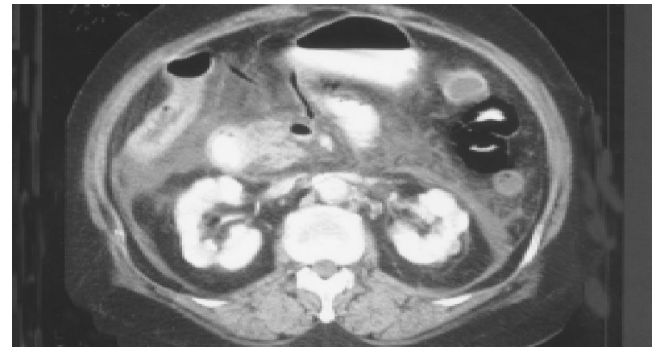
Contrast-enhanced abdominal CT at renal hilar level shows tubular dry gases (arrow) and air-fluid level (arrowhead) within the mesenteric veins. Pneumatosis intestinalis and inflammation fluid collection in the left pararenal space indicating that pancreatitis is also observed.
